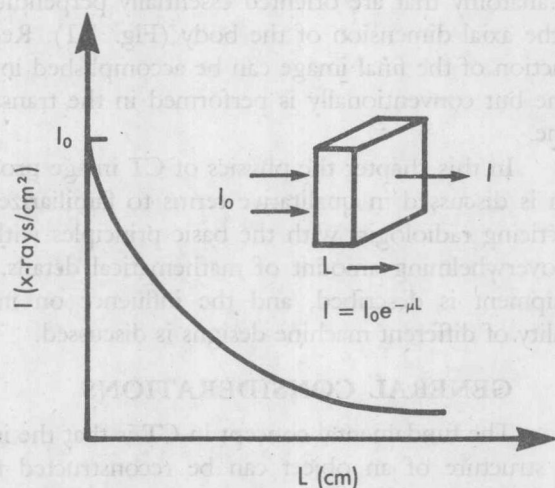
Exponential behavior of x-ray beam attenuation.
